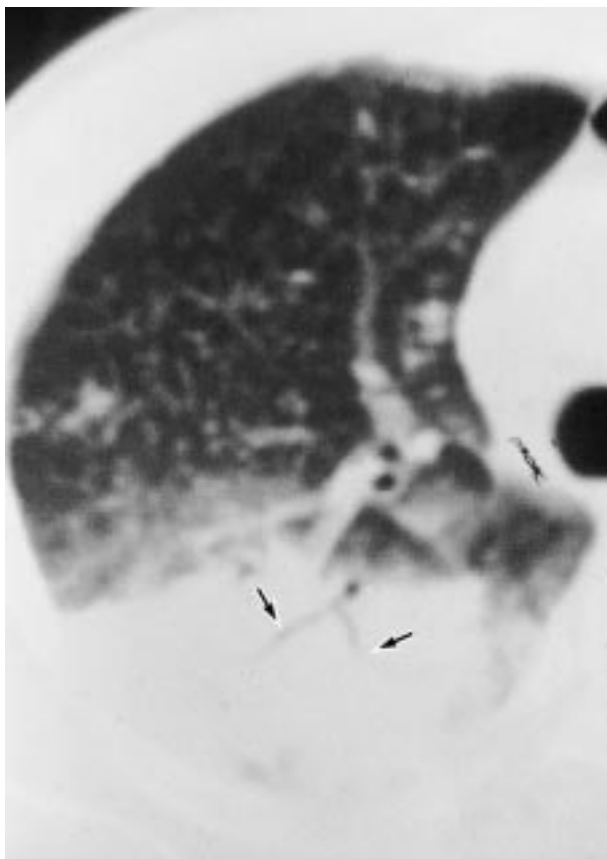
The pre-operative computed tomography findings of consolidation. Air-space consolidation and air bronchogram (arrows) are shown.
